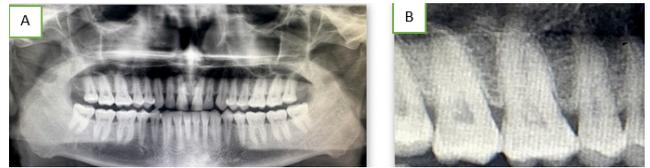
A: Orthopantomograph (OPG); B: IOPAR wrt 15,16,17
